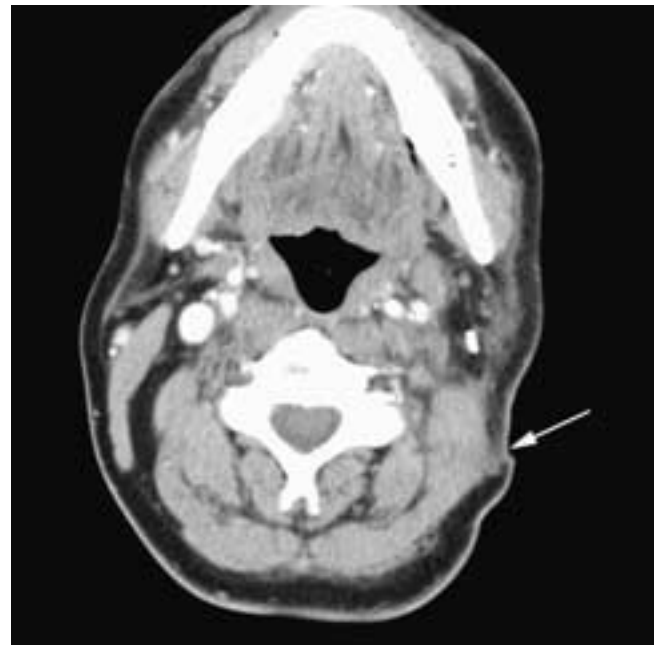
Axial contrast-enhanced CT scan on a patient who had a left radical neck dissection. A surgical clip is seen in the left neck. Note the thin scar line (arrow) and the relatively small amount of fibrosis within the subcutaneous tissues. Minimal edematous change is seen in the adjacent subcutaneous tissues.
